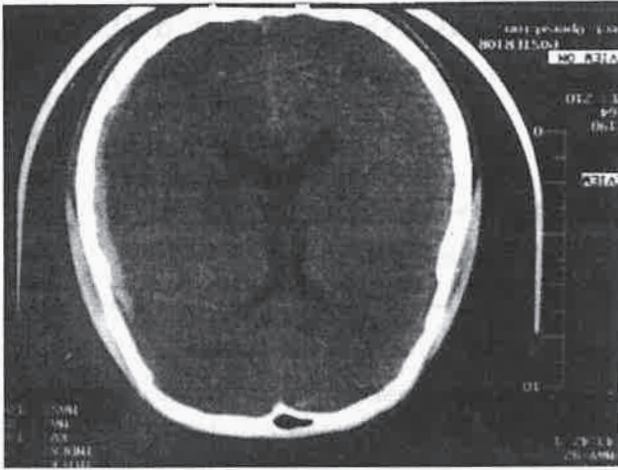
Left temporal and parietal subdural hematoma at the brain computed tomography.
